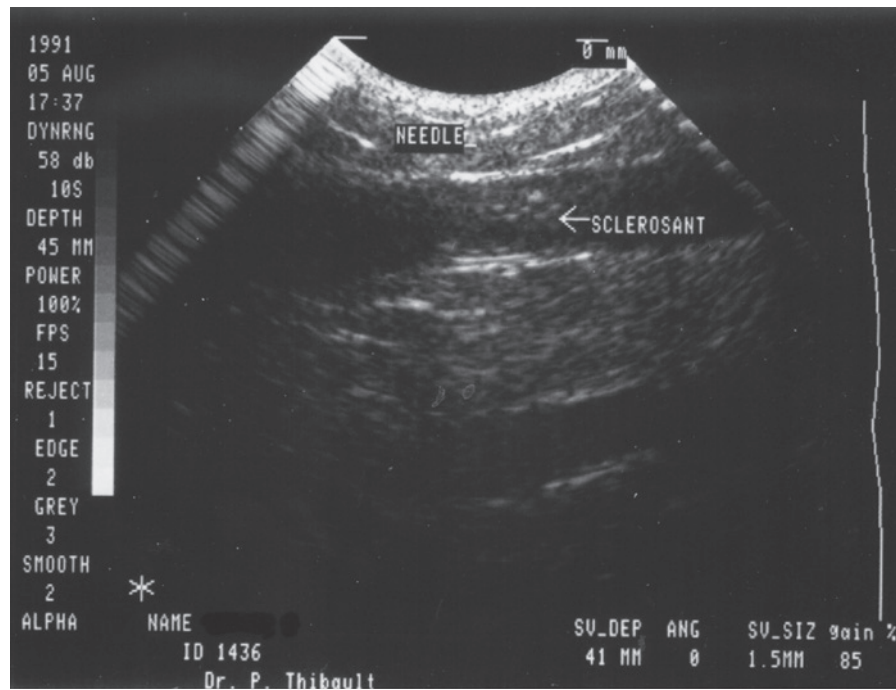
B-mode ultrasound image of needle located in vein with sclerosant flowing toward the right of image. (From Thibault PK, Lewis WA. *J Dermatol Surg Oncol.* 1992. 18: 895–900.)
